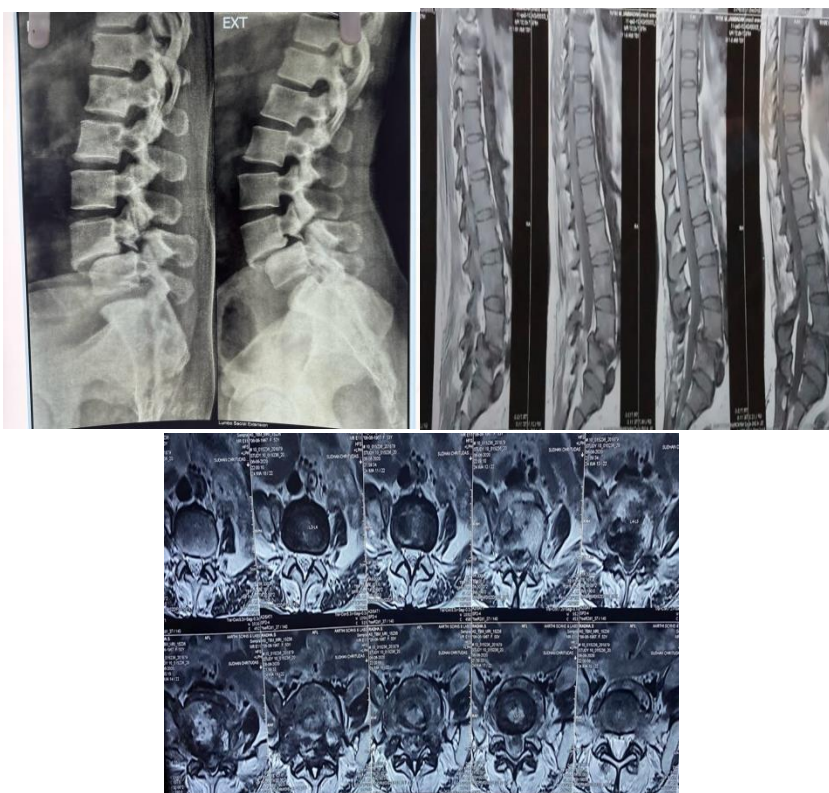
1B, and 1C PREOPERATIVE XRAY AND MRI OF LUMBOSACRAL SPINE IN SAGGITAL AND AXIAL VIEW
